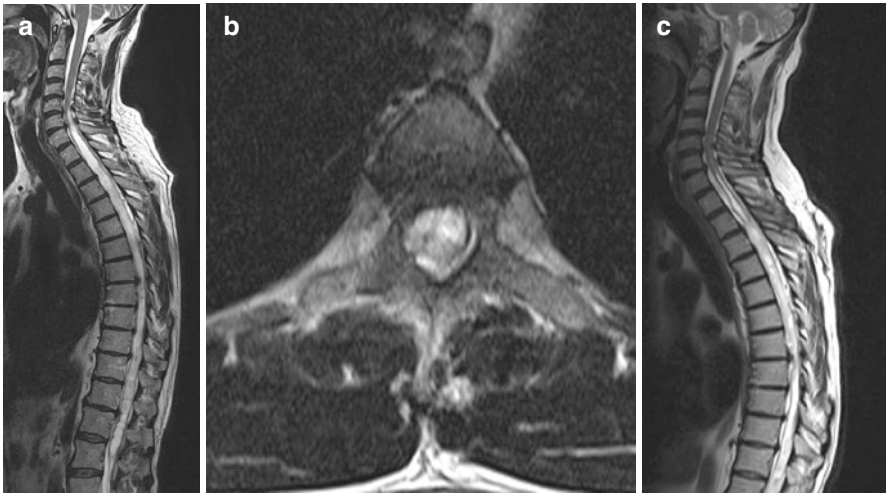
(a) T2-weighted MRI scan of a 66-year-old man 5 years after suffering from a listeria meningitis. After recovery from this inflammation, the patient experienced a progressive paraparesis and ascending neurological deficits threatening his hand functions. The syrinx had reached up to C6. (b) The meningitis had led to severe arachnoid scarring around the entire cord from Th3 to Th10 as shown on the axial scan. (c) After placement of a thecoperitoneal shunt at the cervicothoracic junction lowering the subarachnoid pressure above the arachnopathy, the cervical and upper thoracic part of the syrinx has decreased as shown on this MRI after 6 months
